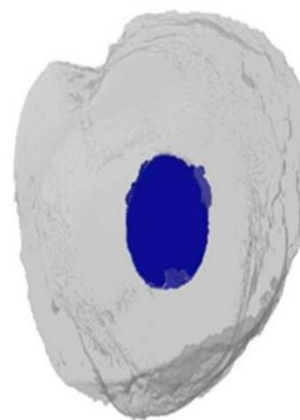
Post-cementation post space volume assessment using micro-computed tomography.
